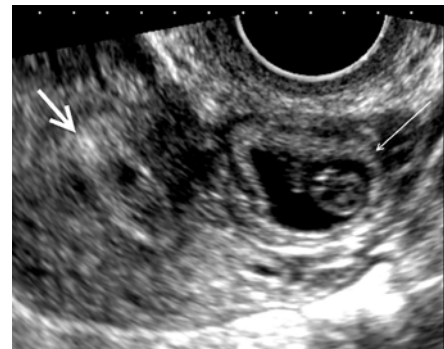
Sagittal ultrasound view of scar ectopic (thin arrow), distinct from endometrial cavity (thick arrow).
